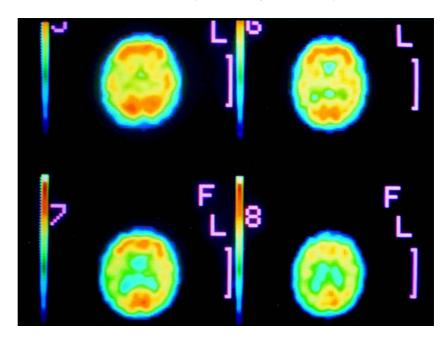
(patient 1). Right temporo-parietal hypoperfusion disclosed by SPECT.
